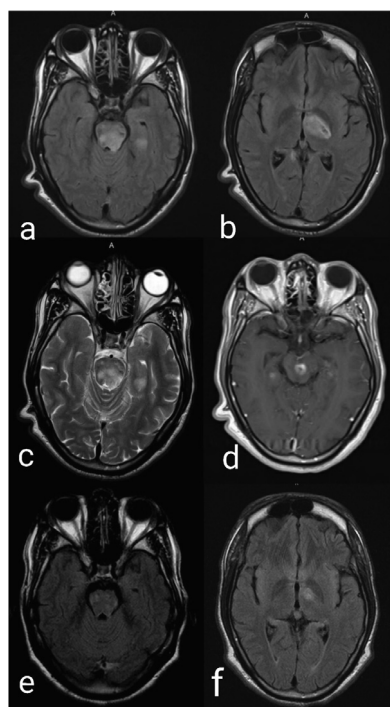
Brain MRI FLAIR and T2 sequences show multifocal abnormal lesions involving the bilateral cerebral hemispheres, left thalamus, and brainstem (a–c). There was an enhancing brainstem lesion (d). Repeat imaging after 3 weeks showed significant improvement of brainstem and thalamic lesion (e,f).
